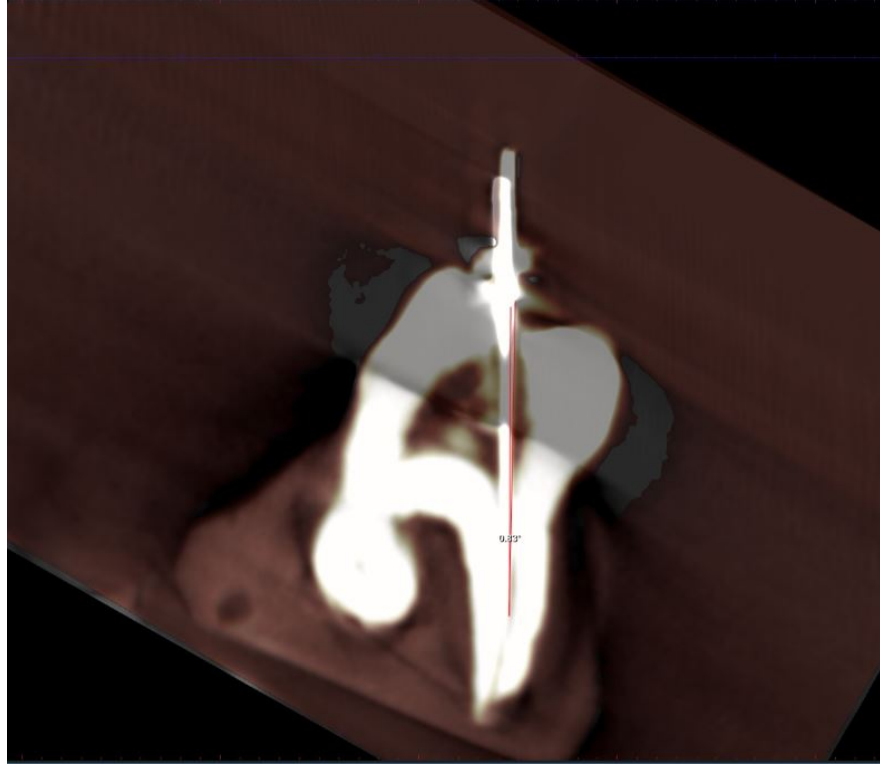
Overlapped CBCT scans in the sagittal view of file in place in both tooth with and without crown present.
